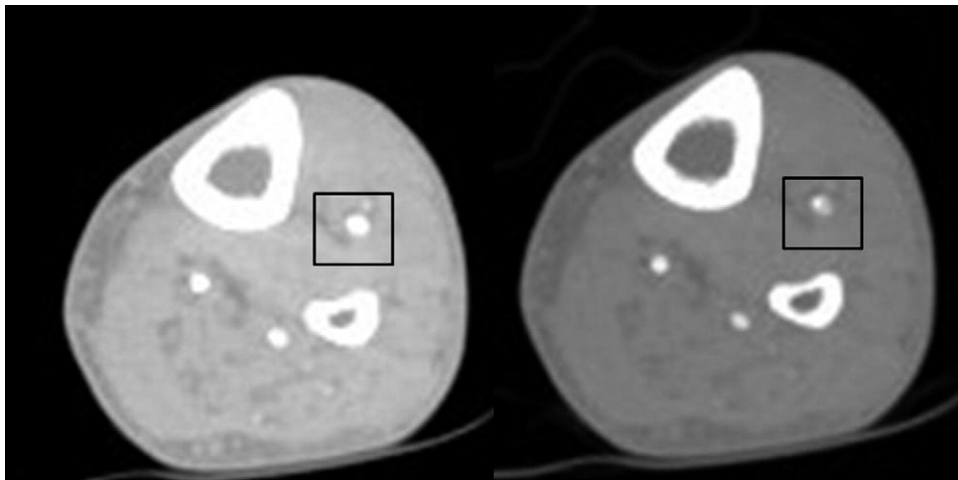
Axial images of a computed tomography (CT) angiogram of the distal lower extremity through the proximal portion of the anterior tibial artery (within the *boxes*). In the image on the *left*, setting the window level with too much brightness makes it impossible to differentiate calcium from contrast giving the appearance that the anterior tibial artery is occluded. In the image on the *right*, after decreasing the brightness, the anterior tibial artery can be seen to be patent with contrast visible within the lumen adjacent to a calcified plaque.
